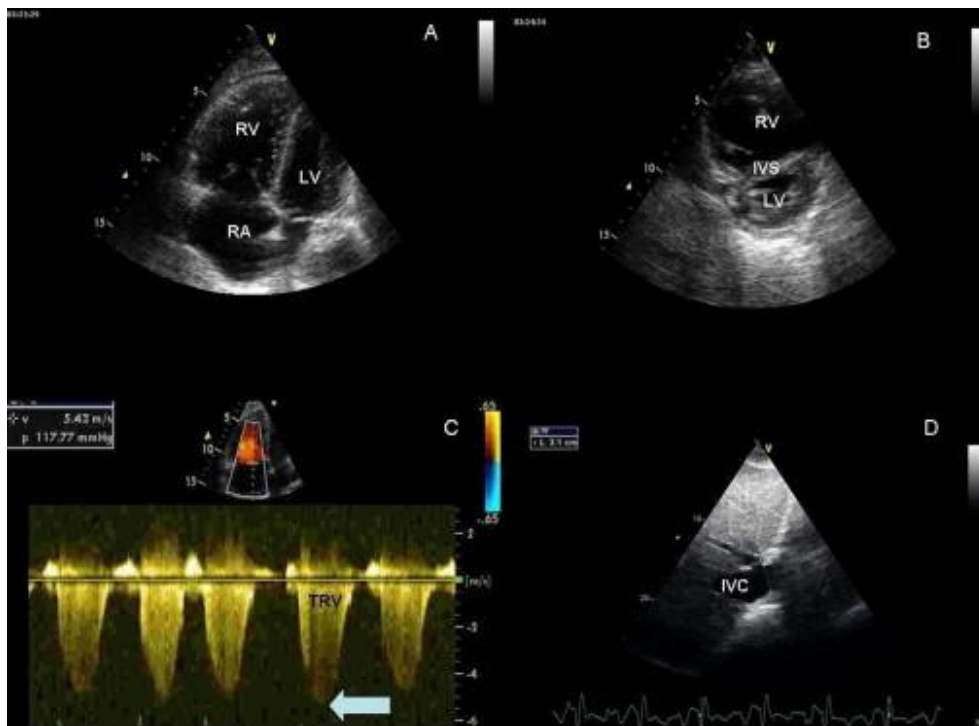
Echocardiogram for Pulmonary Hypertension (17)
